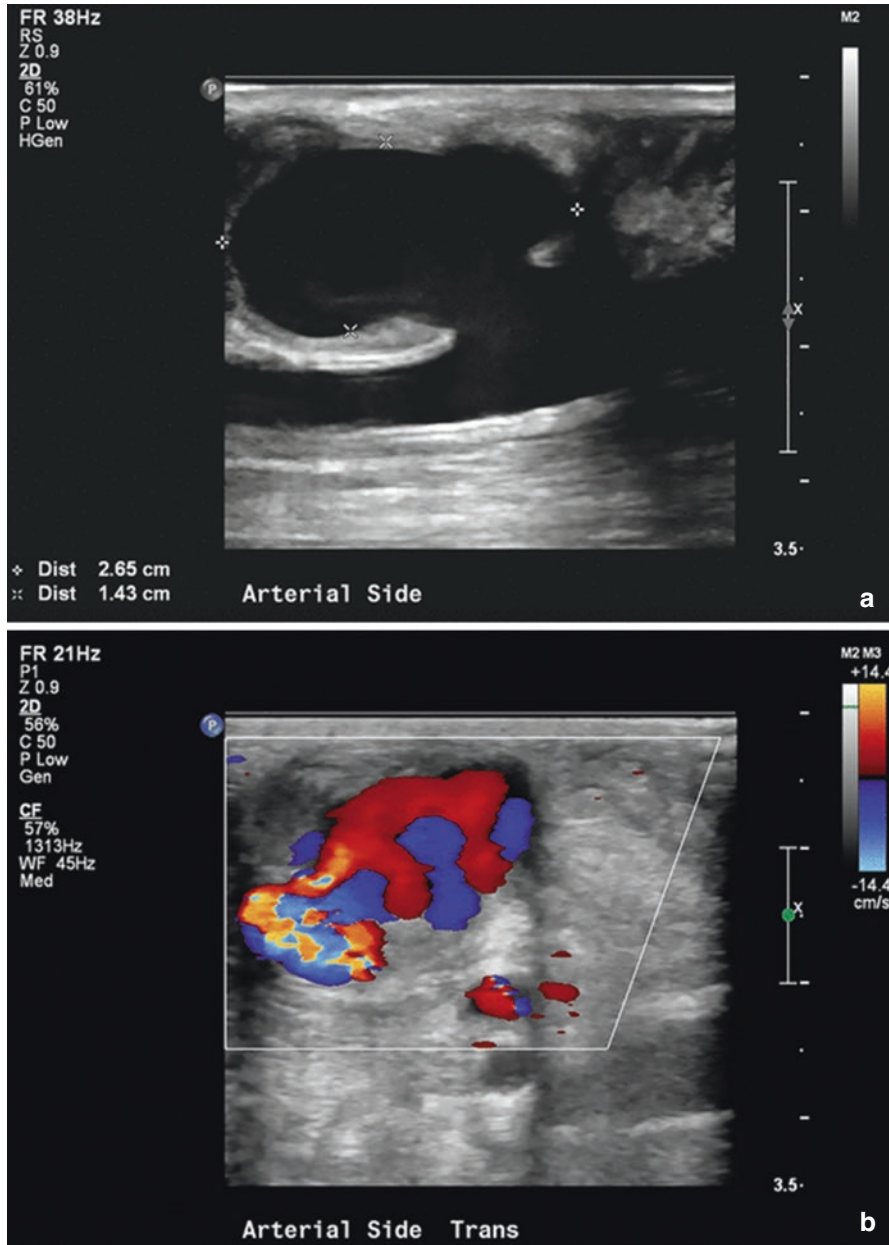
Gray scale or B-mode ultrasound image of an access site pseudoaneurysm. The aneurysm is lobulated and measures 2.7 cm × 1.4 (a). This pseudoaneurysm demonstrates flow within it on color Doppler in a different scan plane (b)
